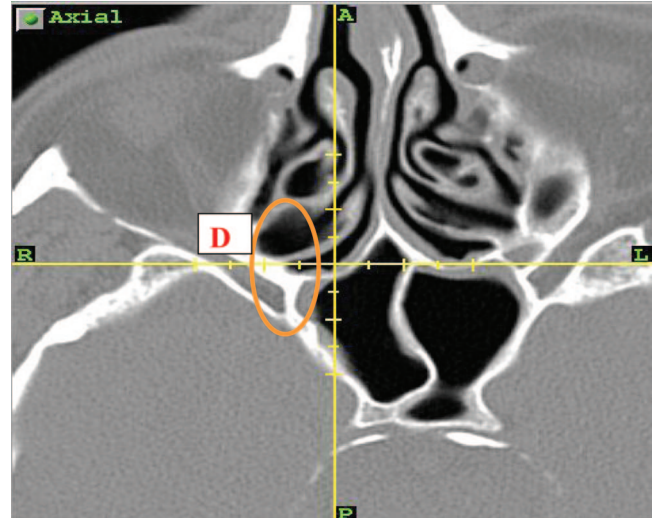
Axial computed tomography cut at the level of sphenoid natural ostium showing type D superior turbinate attachment.
